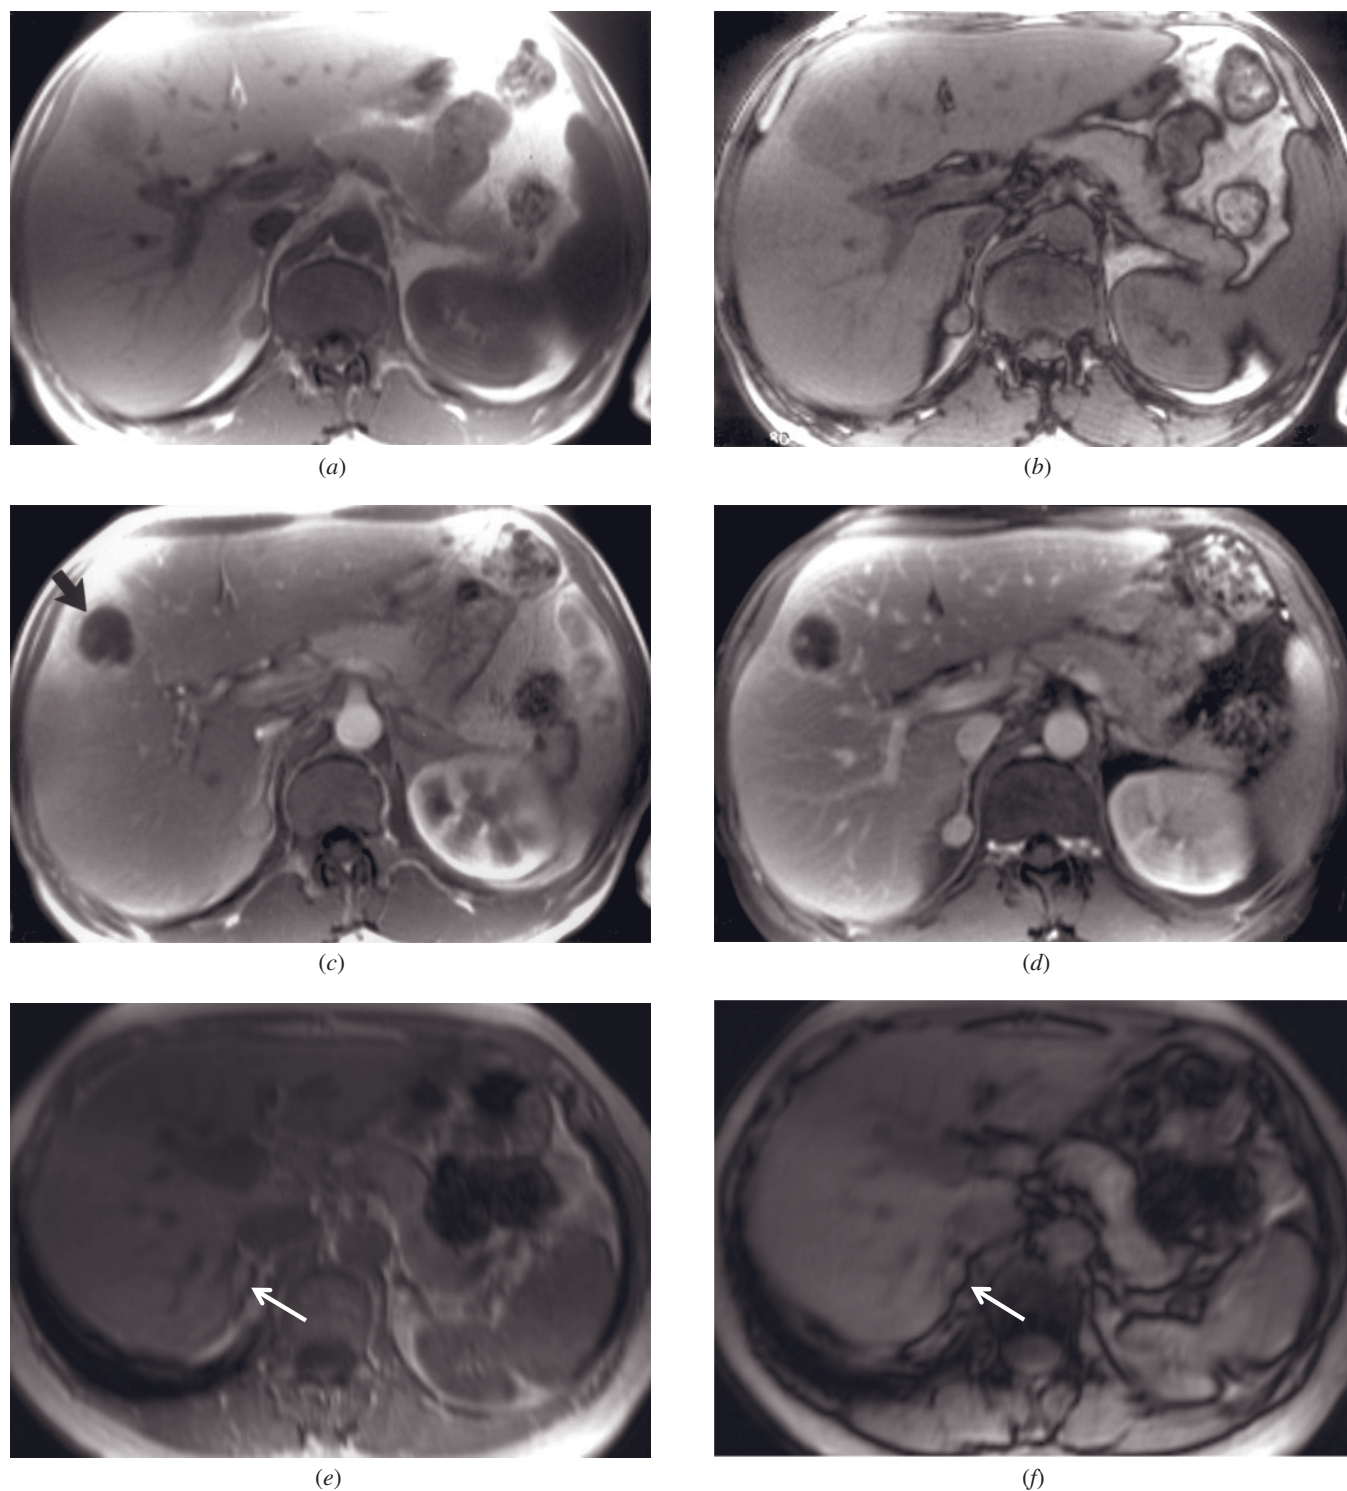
Adrenal adenoma—no signal loss and capillary blush. T1-weighted GE (a), T1-weighted out-of-phase GE (b), immediate postgadolinium GE (c), and 90-s postgadolinium fat-suppressed GE (d) images in a patient with a nonfunctioning adenoma. The adrenal adenoma is slightly hypointense to the liver on T1 (a) and has no signal drop on the out-of-phase image (b). After gadolinium administration, there is a capillary blush of the adrenal adenoma (c) and minimal washout of contrast material on the late image (d). A 3.5-cm abscess with a thin capsule is present in the liver (arrow, c). Note the intense perilesional enhancement on the immediate postgadolinium image. Adrenal adenoma—no signal loss/Dixon method/capillary blush. T1-weighted in-phase (e), out-of-phase (f), water-only (g), and fat-only (h) images of Dixon technique and T1-weighted postgadolinium
